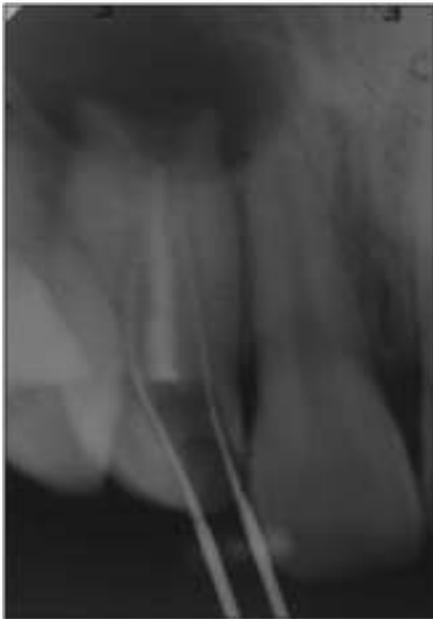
Radiograph Showing Central Canal And Rudimentary Canals.
